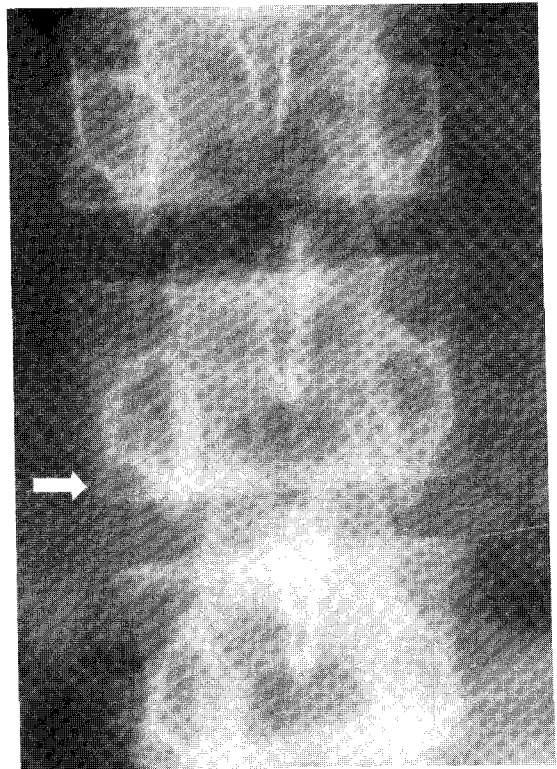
Radiograph of anteroposterior lumbar spine shows vertical striation in vertebral body and contour bulging of left lateral cortex (arrow) of L3. Left pedicle of L3 is asymmetrically enlarged and has dense fuzzy margin.
